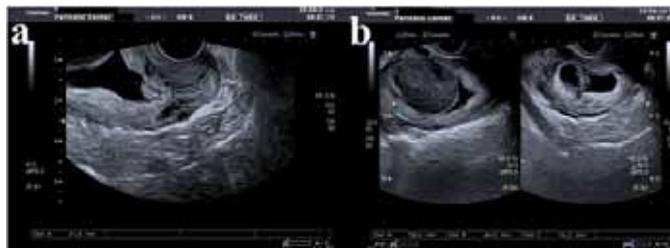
Ultrasound on the day of the patient admission at the Perinatal Center: (a) cervix shortening, chorion frondosum presentation just above cervical M-echo, (b) subchorionic hematoma in uterine cavity above the gestation sac.
